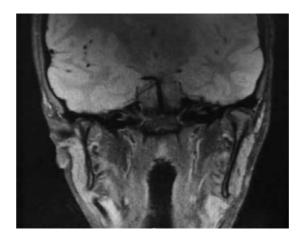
An MRI coronal view of a patient with left TMJ pain and hypomobility. The view shows left disk displacement toward the anterior-medial aspect.
